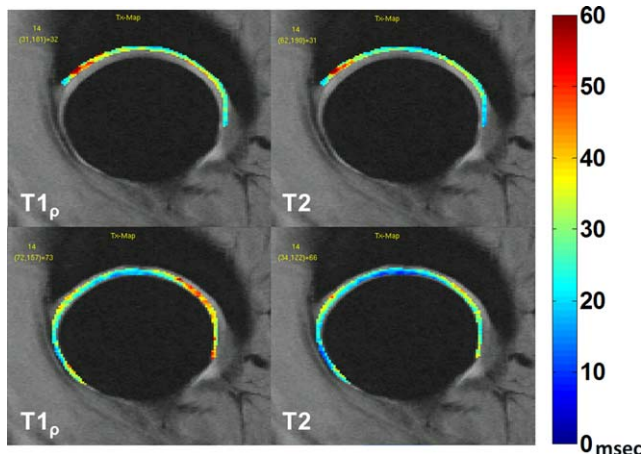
$T1\rho$ and T2 maps overlaid on magnetic resonance images acquired using multiecho spoiled gradient-recalled acquisition in the steady state, showing femoral cartilage (top) and acetabular cartilage (bottom) of the right hip of a subject with a Kellgren/Lawrence radiographic damage score of 2 (same subject as in Figure 1). The color map corresponds to the range of relaxation times (in msec).
